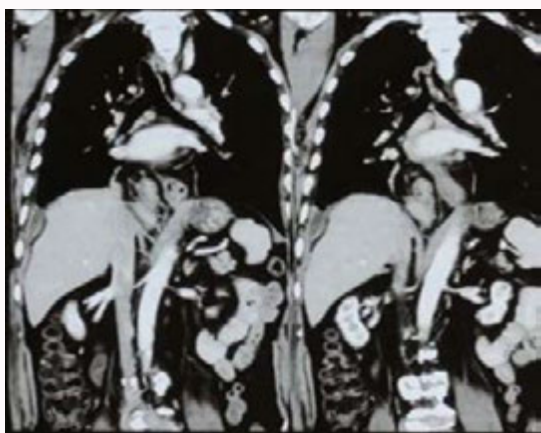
Computed tomography image showing volvulus and paraesophageal hiatal hernia.
